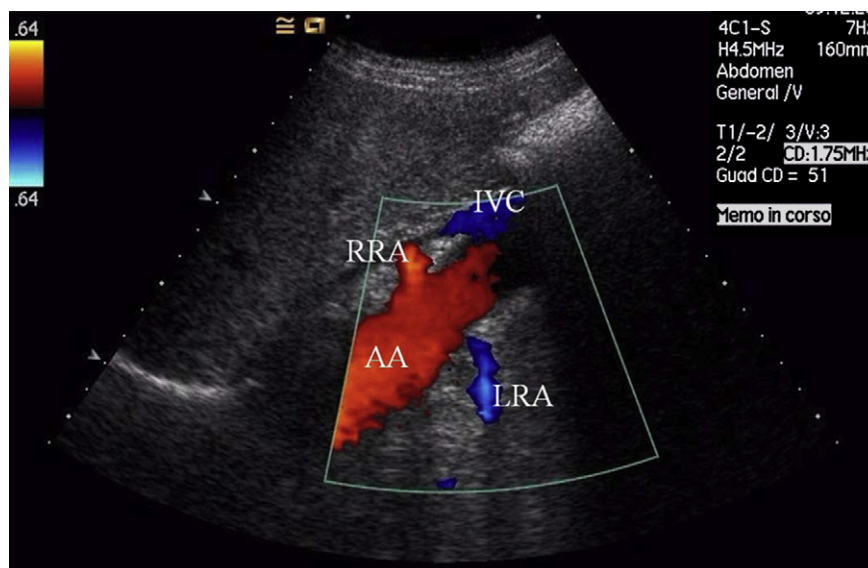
Color image of the ostium (arrows) in both RAs arising from the aorta using the “banana peel” technique. The Doppler beam angle is optimized and close to zero. The right RA is depicted in red, the left RA in blue. Abdominal aorta (AA), left RA (LRA), right RA (RRA), inferior vena cava (IVC).
